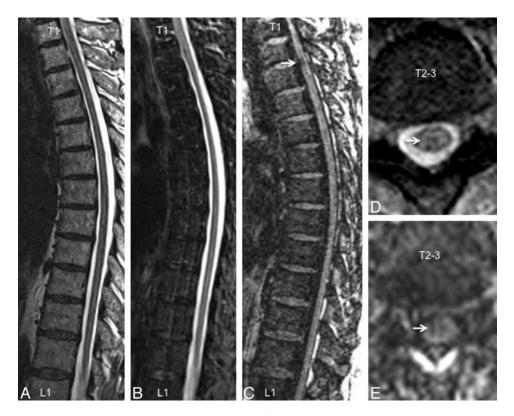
A comparison of imaging techniques for visualization of thoracic cord lesions in a 45-year-old woman with relapsing-remitting MS. Just as in the cervical cord, T1-weighted MPRAGE (*C*) performed better than routine clinical T2-weighted FSE (*A*), STIR (*B*), and T2*-GRE (*D*) for visualization of lesions. The lesion denoted by an arrow has a typical appearance and could be confirmed on axially reformatted T1-MPRAGE images (*E*).
